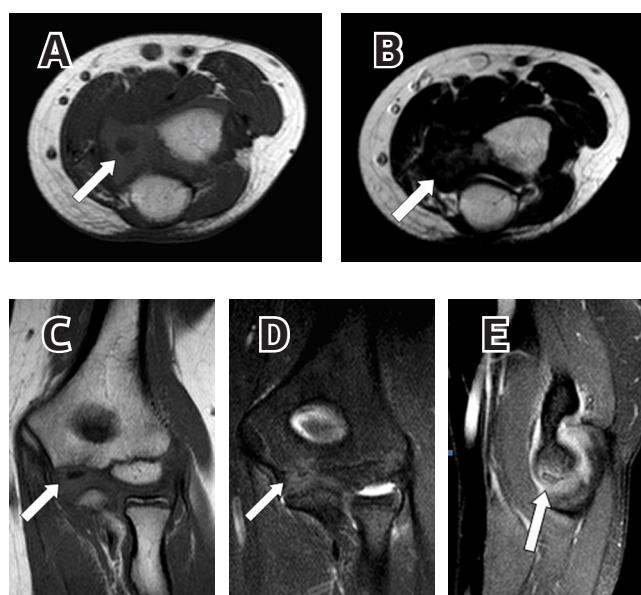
Right elbow axial T1 MR image showing avascular necrosis of the trochlea (A). Right elbow axial T2 MR image showing patchy avascular necrosis of the trochlea (B). Right elbow coronal T1 MR image showing the affected part of trochlea (C). Right elbow coronal T2 MR image showing the trochlear avascular necrosis (D). Sagittal T2-weighted MR image of the elbow delineating the lesion of the trochlea and effusion in the joint space (E).
